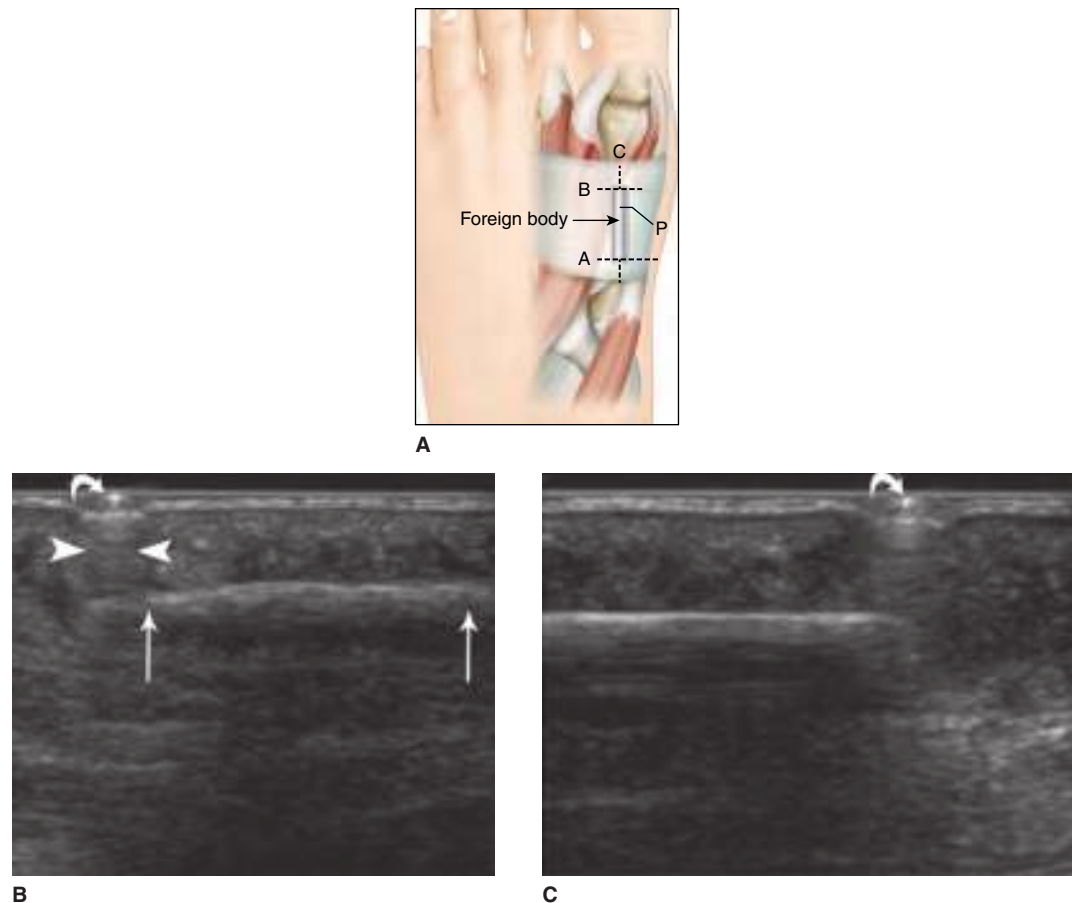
Paper clip localization of a FB. A. The transducer (P) is placed over the FB. (A = proximal end of FB, B = distal end of FB). B. US of the FB (arrows). The paper clip (curved arrow) is seen at the proximal end of the FB with a comet tail artifact (arrowheads). C. US through the distal end of the FB. The paper clip is again seen (curved arrow). (Used with permission from Creel SA, Girish G, Jamadar DA, et al: Sonographic surface localization of subcutaneous foreign bodies and masses. *J Clin Ultrasound* 2009; 37:158–160.)
